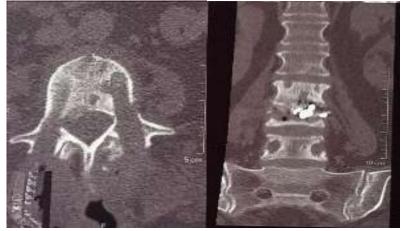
CT scan showing bone resorption around removed transpedicular screws.
